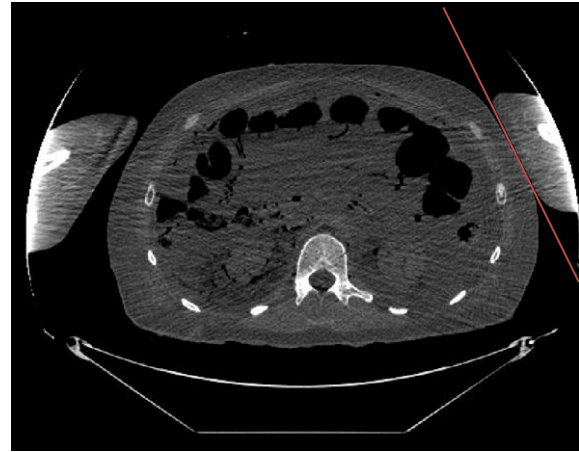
Soft tissue region when torso and CT bed are not separated by CT scanner bed method 2.
